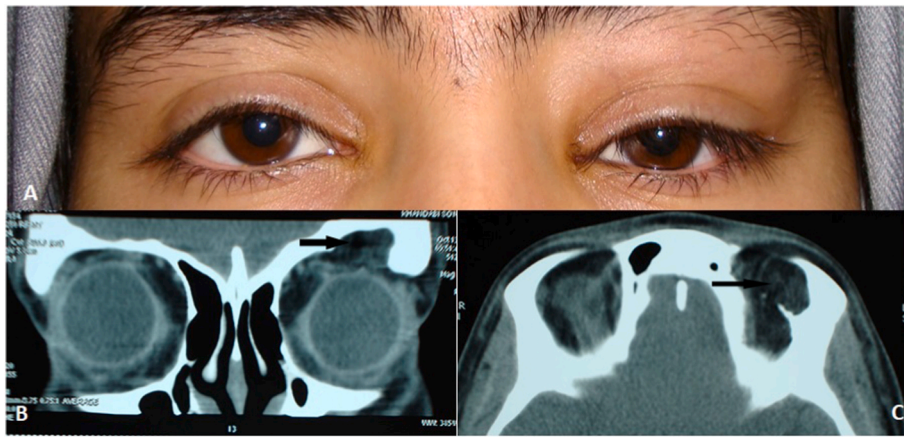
22-year-old female with intraosseous dermoid cyst (Case NO.2). A: Clinical image of the patient presented with left ptosis and upper lid puffiness. B: Coronal orbital computed tomography (CT) shows an irregular heterogeneous mass located superolateral in the left orbit. C: Axial orbital CT image of the same patient.
